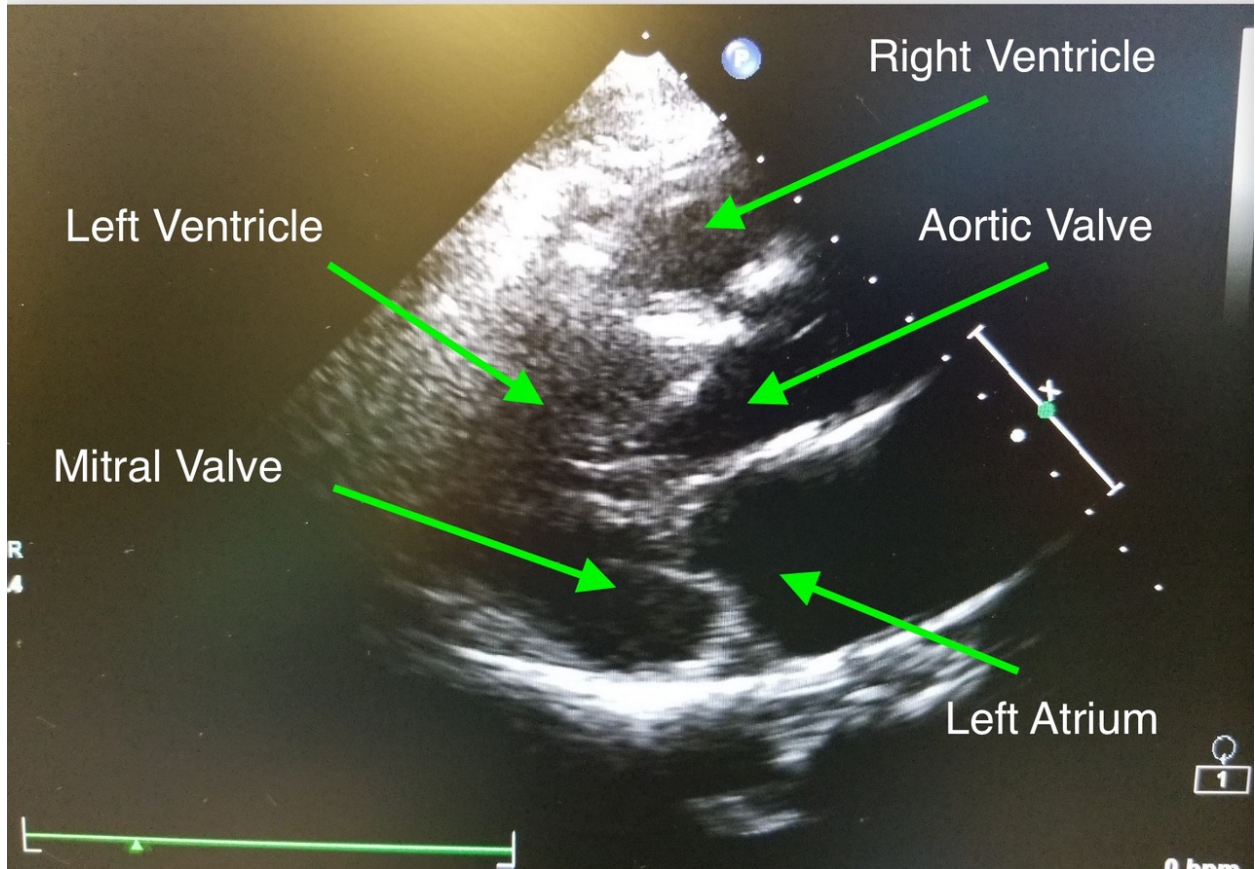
Transthoracic echocardiogram image of the parasternal long axis view taken after combined spinal-epidural placement (CSE)
